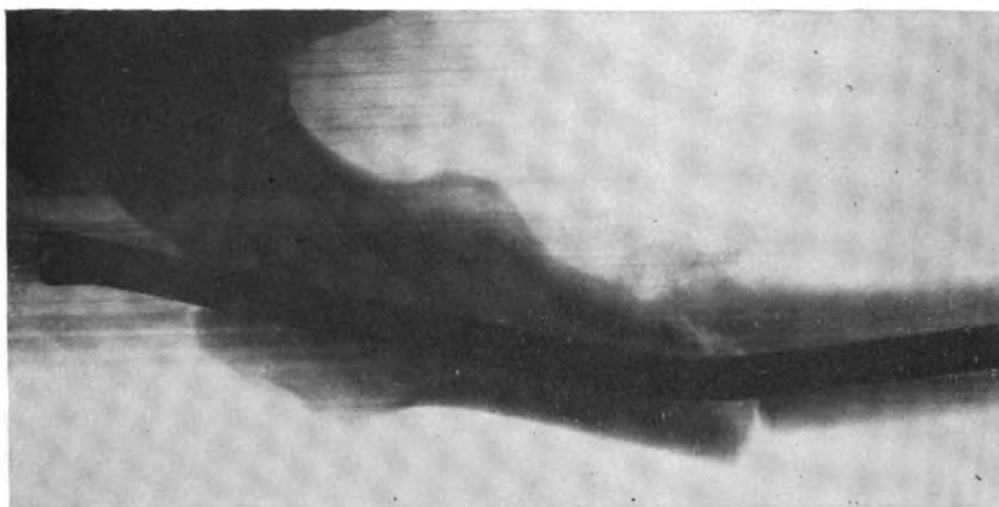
Case 3. Postoperative anterior-posterior x-ray at 4 weeks.
